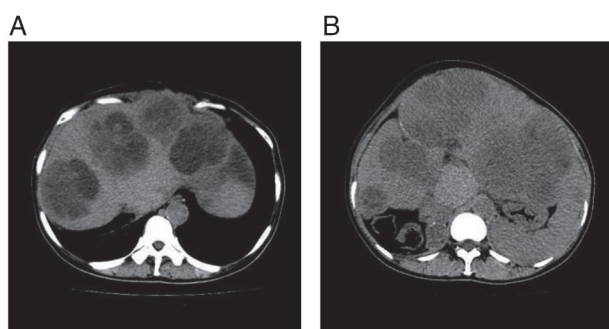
CT enhanced images of the upper abdomen at four years after surgery. (A) There was a progressive enlargement of the liver, obvious increase, enlargement of intrahepatic metastases and uneven density. (B) The mass in the right adrenal area was similar to that before and there were spotted calcifications.
